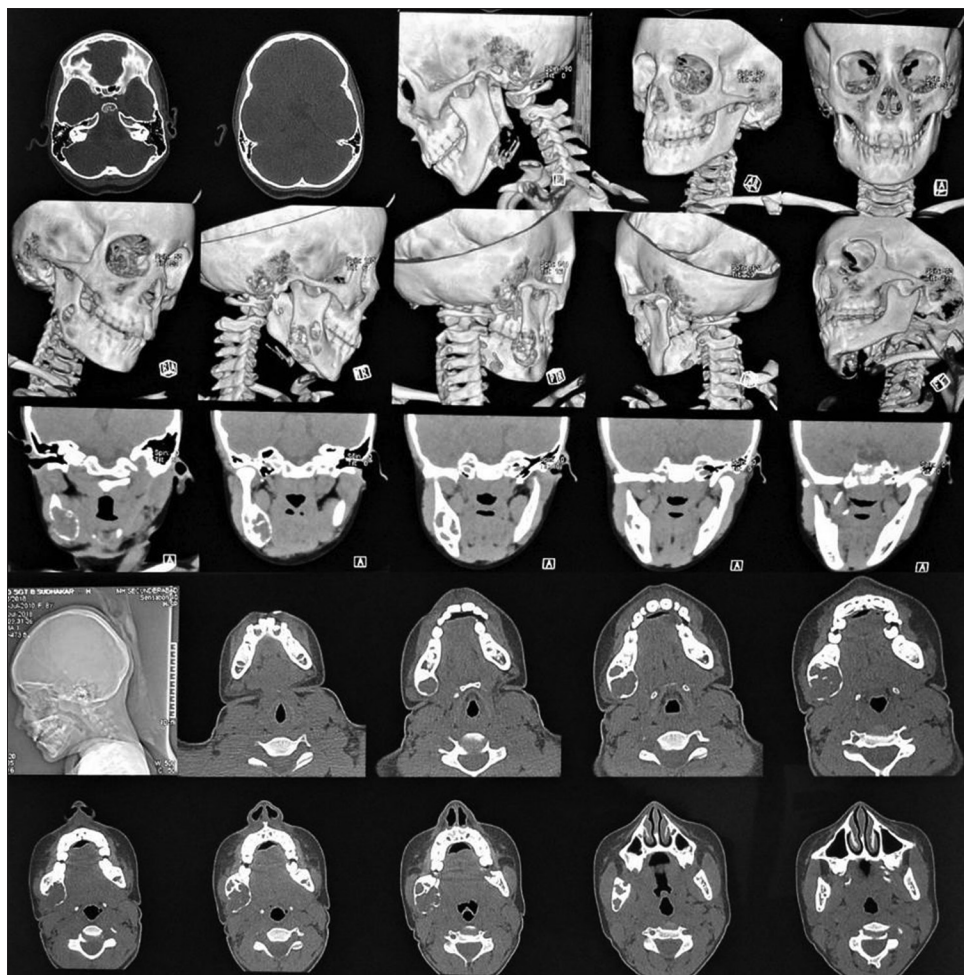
Noncontrast computed tomographic scan revealed a multiloculated expansile cystic lesion with bony septae within, measuring 2.6 cm × 2.5 cm × 3.7 cm (AP × Tr × CC) in the region of the right angle of the mandible. Overlying cortex was thinned out with breaches of its integrity at places
